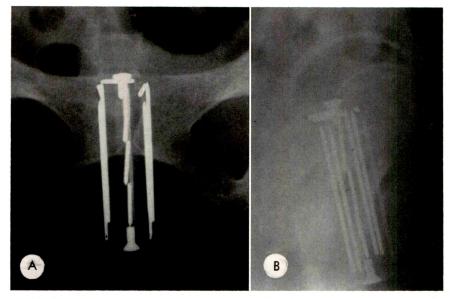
Case II. (A) Anteroposterior roentgenogram of pelvis showing loading for anterolateral vaginal wall metastatic disease. (B) Lateral view.
